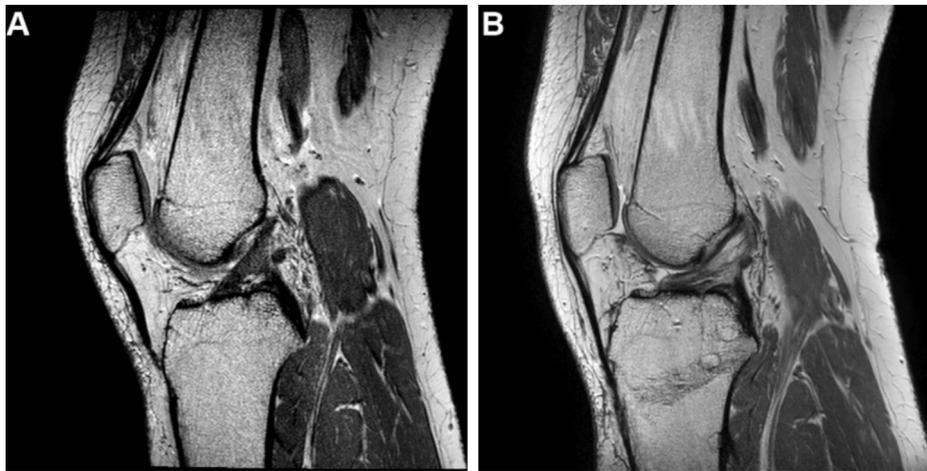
Example of postoperative morphologic ACL change: mucoid degeneration (left side of knee) (A) preoperative sagittal MRI image, (B) postoperative sagittal MRI image. (Postoperative image also shows a ganglion cyst in an ACL).
